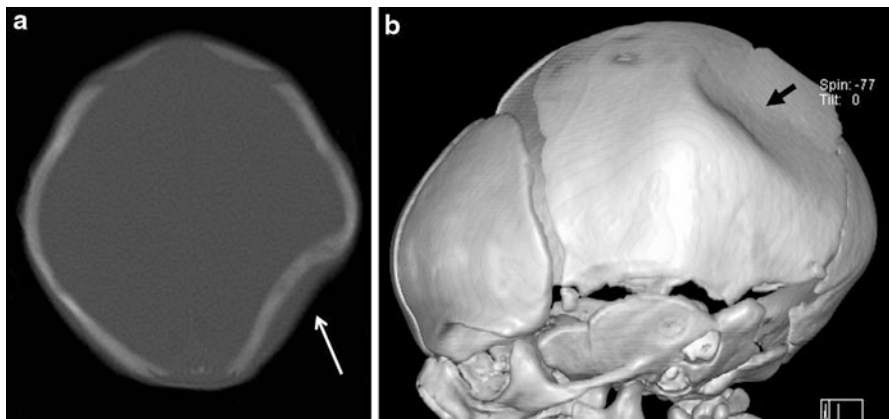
“Ping-pong ball” deformation of the skull (*arrows*) depicted by axial computed tomography (CT) (a) and three-dimensional CT reconstruction (b). Note continuity of the inner and outer skull tables. The patient was a term infant delivered by non-emergency Cesarean section for non-progressing labor. Caput succedaneum and a skull depression were noted following delivery. Apgar scores were 8 and 9 at 1 and 5 min (Images courtesy of Tara Holm, MD)
